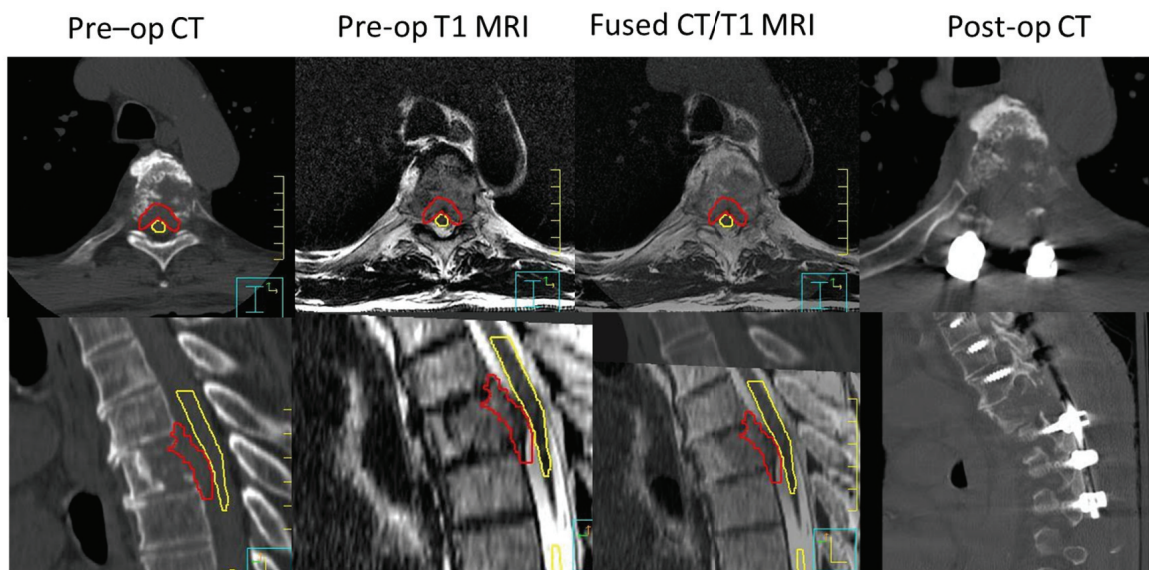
Patient 2: Clinical course – Patient with extensive epidural disease causing compression at T5. T1 MRI was fused to CT for navigation. Postoperative changes seen on CT with bilateral instrumented fusion 3 levels above and below and significant decompression achieved. Epidural disease (red) and spinal cord (yellow) were contoured.
